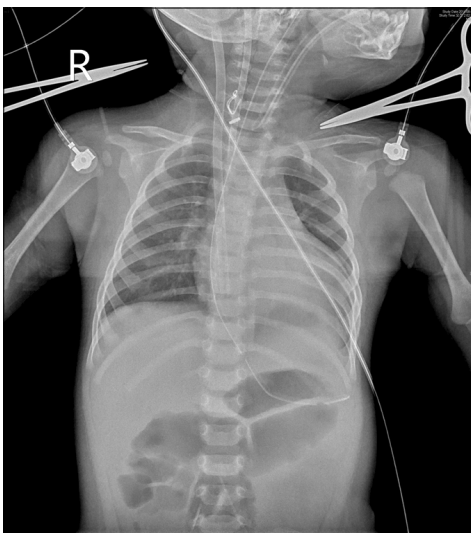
Chest X-ray showed extracorporeal membrane oxygenation support via right neck vessel.
